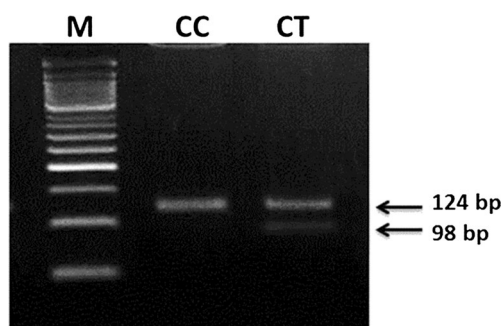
TLR4 1196C/T gen domain as seen in agarose gel; CC, 124 bp; CT, 124+ 98+ 26 bp (a product of 26 bp is not visible in 2 % agarose gel) (M: marker 50 bp).
